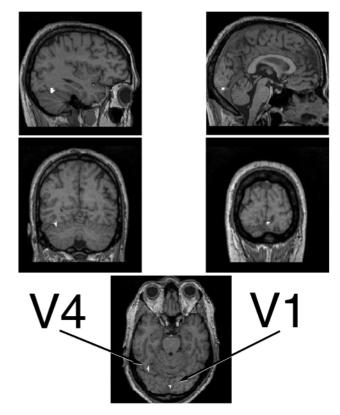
Co-registered structural and functional MRI data from an agematched normal control subject showing activation in the calcarine fissure (V1) on the left and in the fusiform gyrus (V4) on the right. Conventions are as in Fig. 2.
